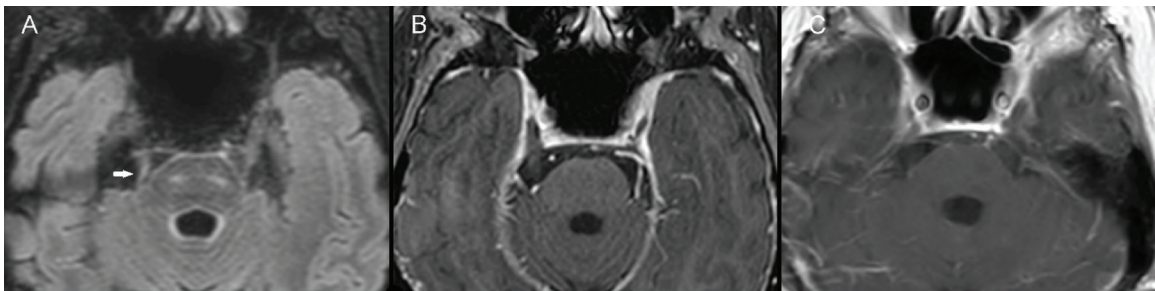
A 76-year-old man with cryptococcal meningitis. (A) Axial CE-3D FLAIR/FS images showed leptomeningeal enhancement along the right cranial nerve V (arrow). There was no leptomeningeal enhancement along the cranial nerve V on CE-3D THRIVE (B) or CE-T1WI (C).
